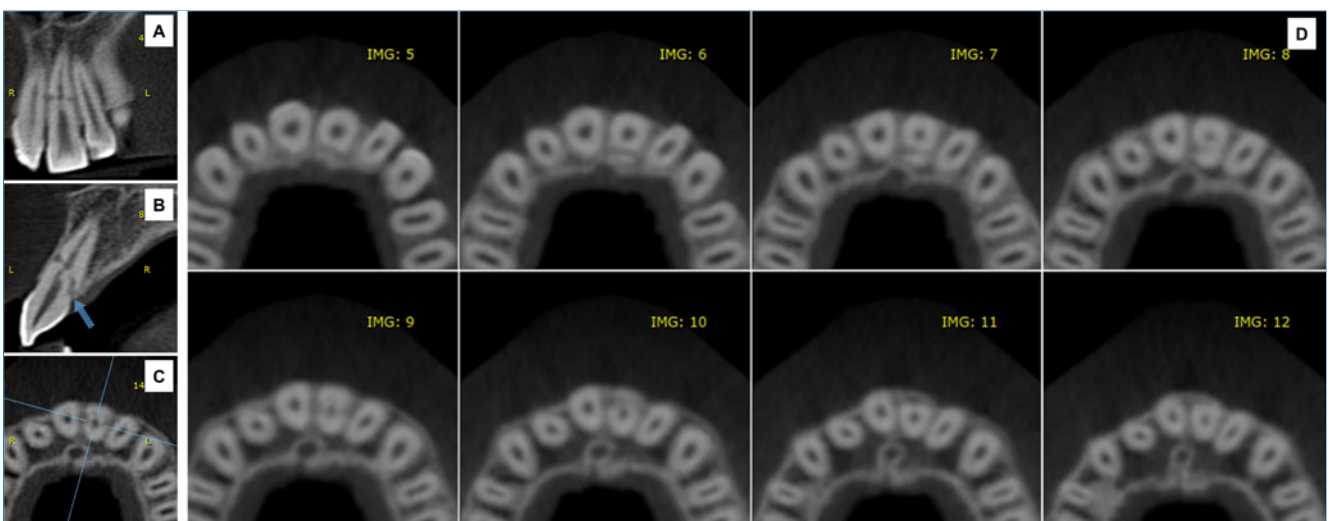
Imaging complementation by cone-beam computed tomography. Bone callus formation is observed between the tooth fragments. (A) Coronal, (B) sagittal, and (C) axial sections.
